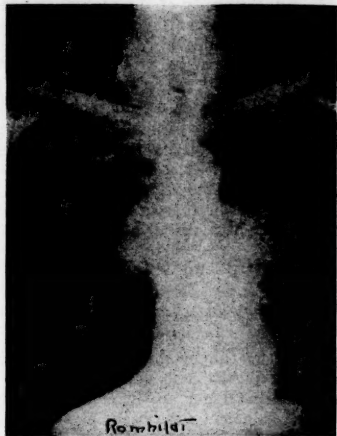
Patient sand-blasted for many years. Extensive pneumoconiosis. First x-ray opinion was pulmonary tuberculosis.
